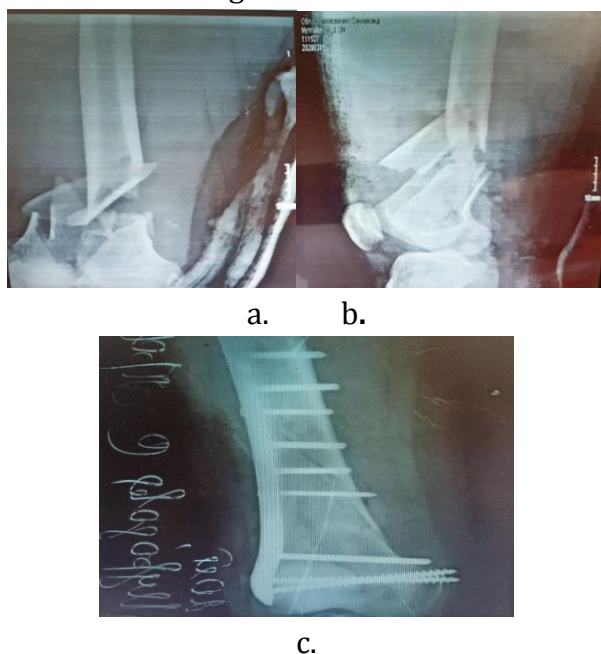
Radiograph of patient C., born 1993. a,b-diagnostic before surgery, c-after surgery, fixation with Liss.
